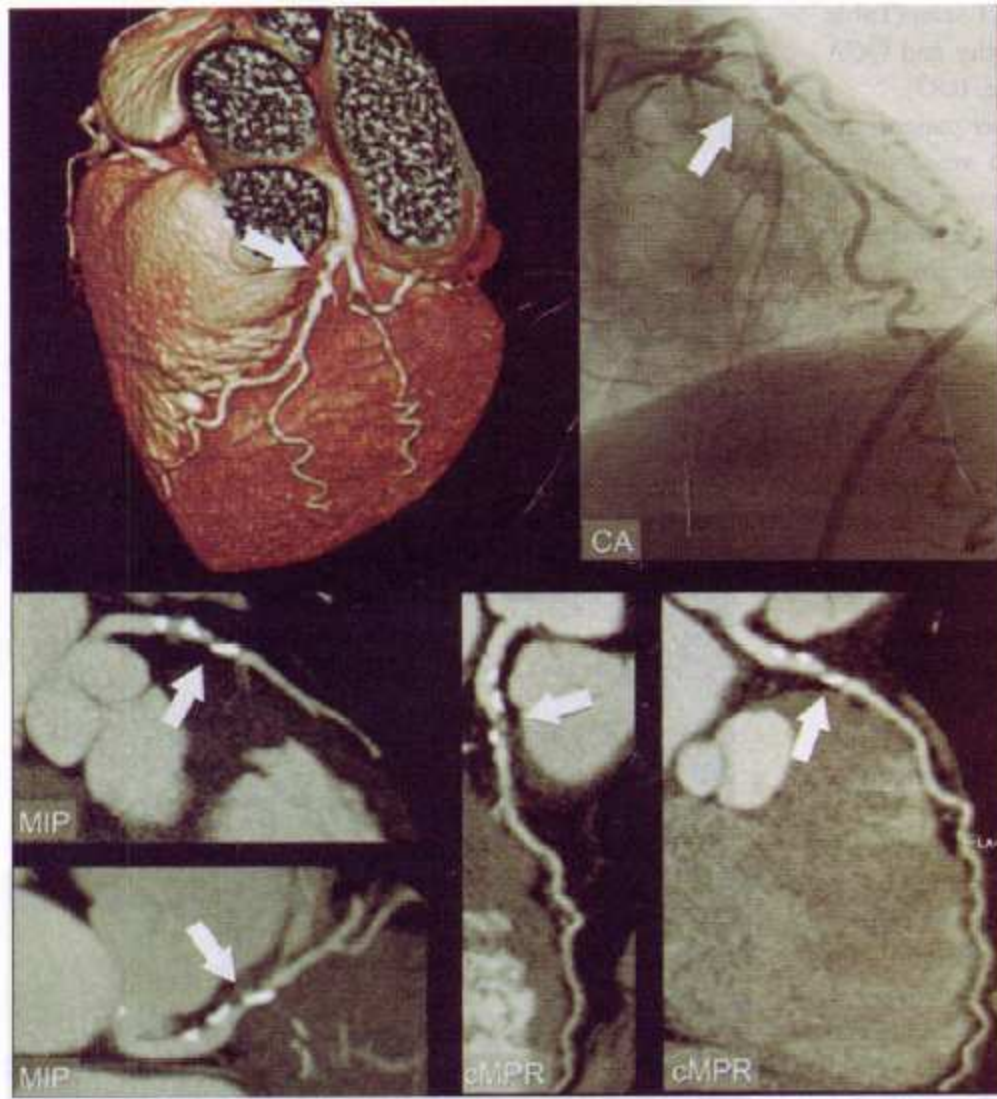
Volume-rendered CT image (colored image) providing an overview of the coronary anatomy and suggesting a significant stenosis of the proximal LAD (indicated by the arrow). More detailed analysis using different CT postprocessing techniques (maximum-intensity projections [MIP] and curved multiplanar reconstructions [cMPR]) confirms the presence of a significant stenosis, which corresponds with the conventional angiogram (CA).
